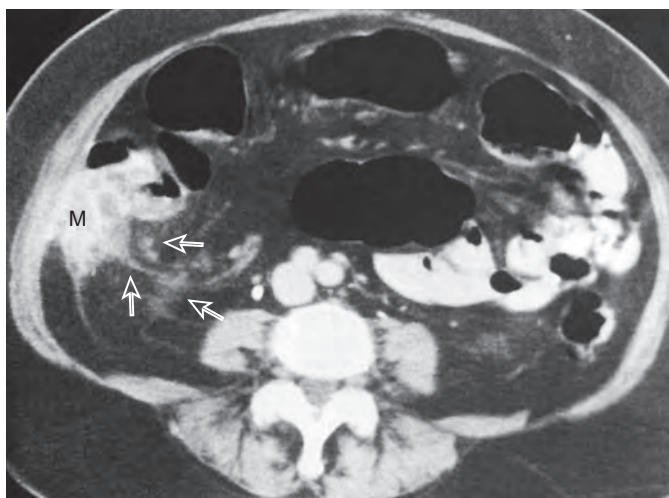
CT scan of perforated carcinoma of the appendix. A lobulated, heterogeneous complex mass (M) is seen posterior and caudal to the cecum. The mass has an irregular contour, and periappendiceal inflammatory changes are present (arrows).
